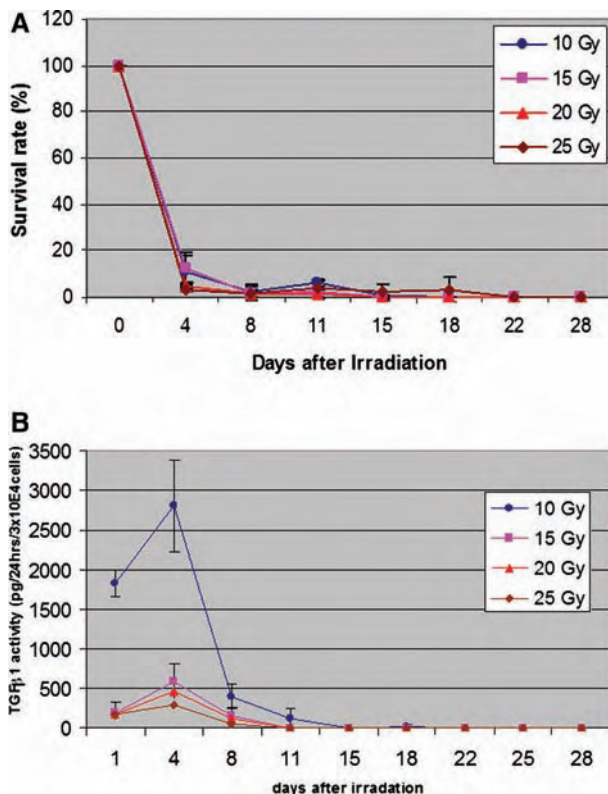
(A) The survival rate (%) of transduced cells irradiated with 10, 15, 20 or 25 Gy of X-ray radiation. For all radiation doses the survival rate dropped significantly in the first 4 days and no surviving cells were detected by day 22. (B) The TGF- $\beta$ 1 expression level increased at day 4 and subsequently declined until reaching undetectable levels by day 22.
